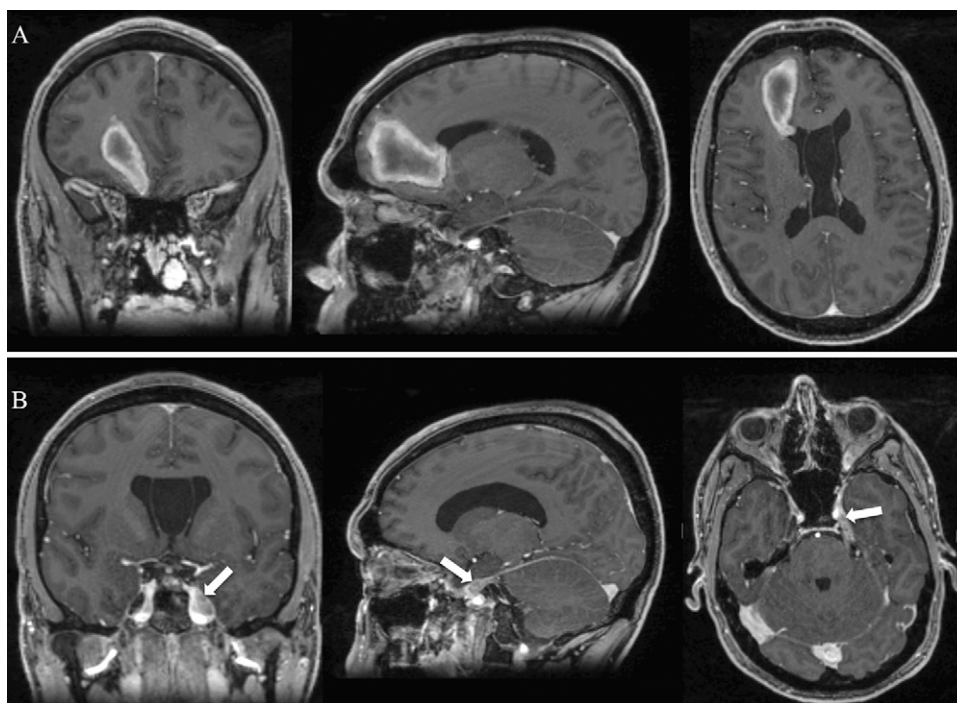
T1 postcontrast MRI of the brain. A: Rim-enhancing right frontal lesion with an associated hemorrhagic component with mild mass effect, shown in coronal, sagittal, and axial planes. B: Enhancing lesion within the left Meckel's cave (arrows), shown in coronal, sagittal, and axial planes.
